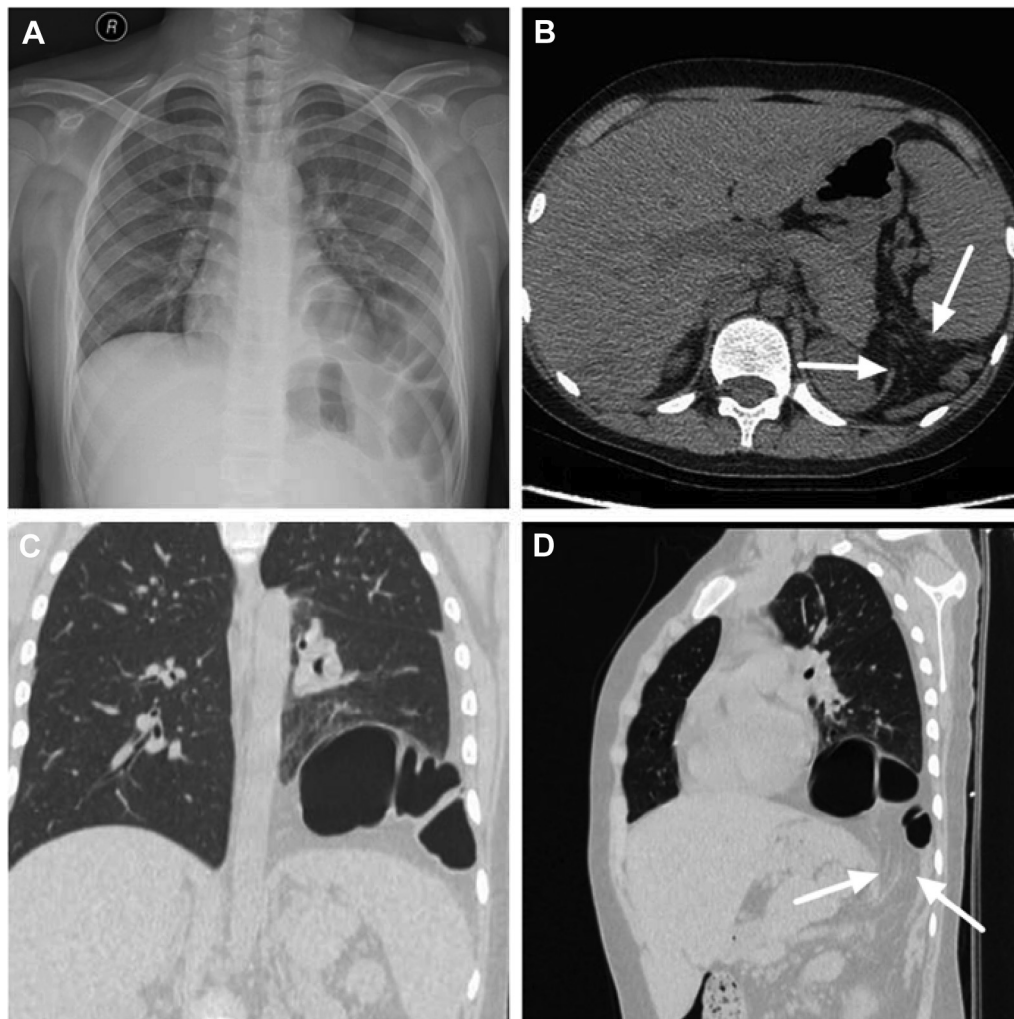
(A) The same patient 20 months postchemotherapy, x-ray showed elevation of the left diaphragm, suspicious of bowel herniation into the thoracic cavity. (B-D) CT scan demonstrated the left-sided diaphragmatic hernia with left colon herniated into the left thoracic cavity, with a clear diaphragm opening (white arrows).
